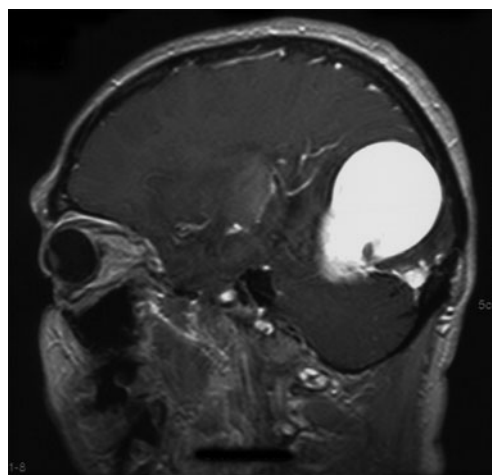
T1 Gadolinium ponderate sagittal magnetic resonance imaging sequence on admission showing an important occipital vascular mass
